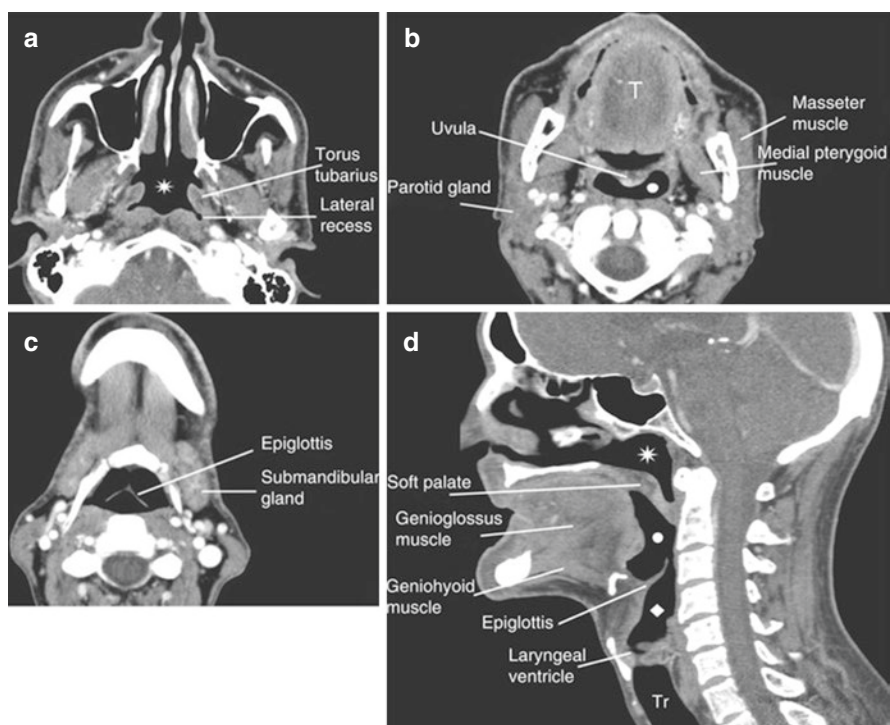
Nasopharynx and oropharynx CT. Axial scan (a–c) and sagittal reconstruction (d). Nasopharynx (*asterisk*), hypopharynx (*rhombus*), tongue (*T*), oropharynx (*circle*), trachea (*Tr*)
